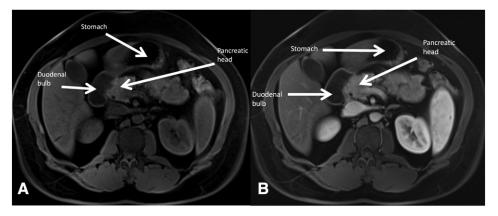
pre-contrast T1-weighted image (A) and arterial phase T1-weighted image (B) of the normal pancreas case showing enhancement of the pancreatic tissue and the visibility of the duodenal bulb.
